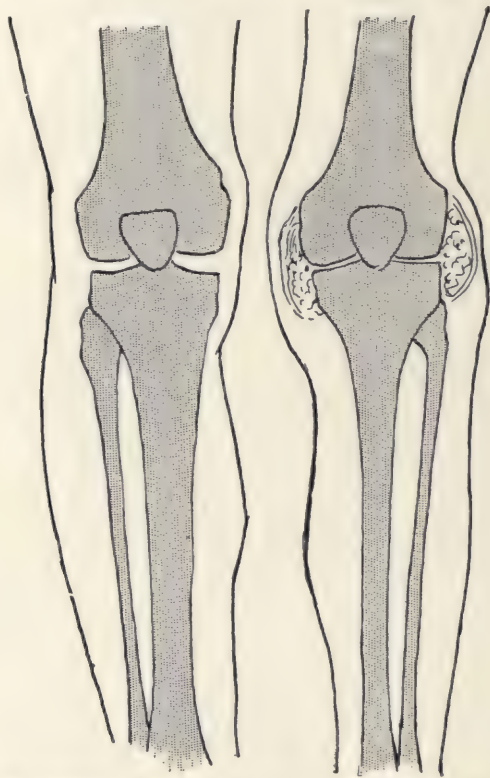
White swelling of the knee (after a radiograph). Atrophy of the bones on the affected side; increase in volume of the knee, proceeding from the distension of the synovial cavity by pulpy masses.—Compare with fig. 1030. Other elements of diagnosis with osteo-myelitis: tuberculosis generally involves the articular extremities; osteo-myelitis nearly always the diaphysis. The onset is insidious in tuberculosis, acute in osteo-myelitis, etc.
